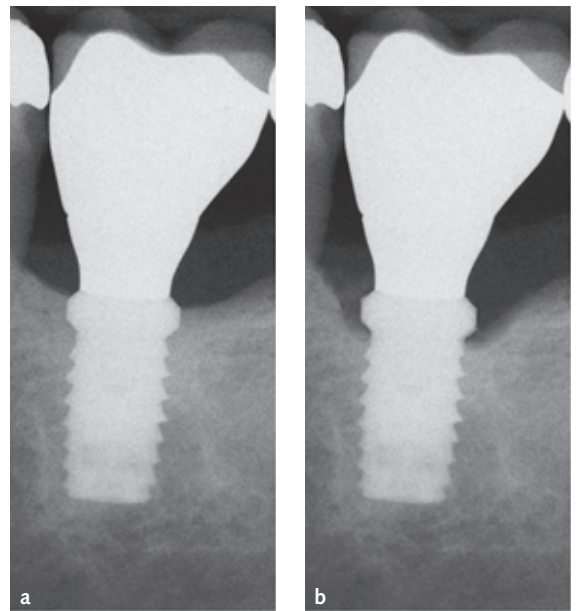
Baseline radiograph of a short implant (8 mm) with no sign of bone loss (a) paired with a follow-up visit at 1 year with 1 mm of bone loss (b).
